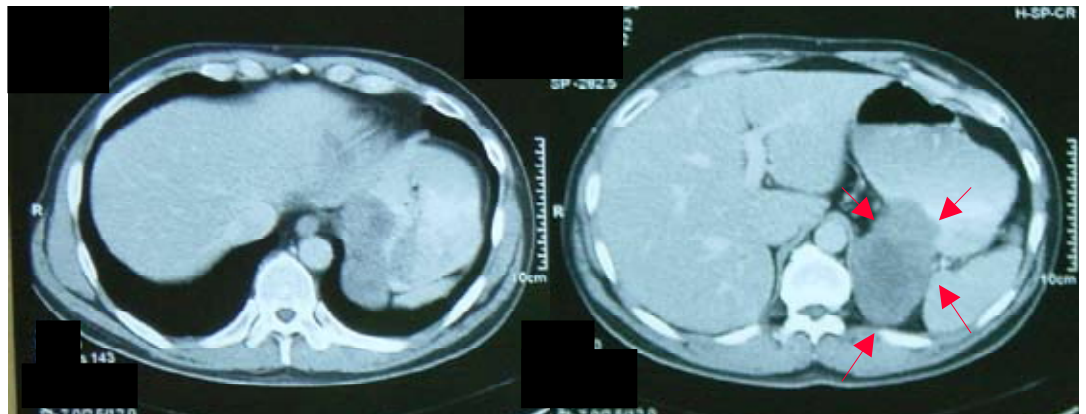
CT of patient with large abdominal mass with central necrosis (courtesy of Mr Simon Toh)
